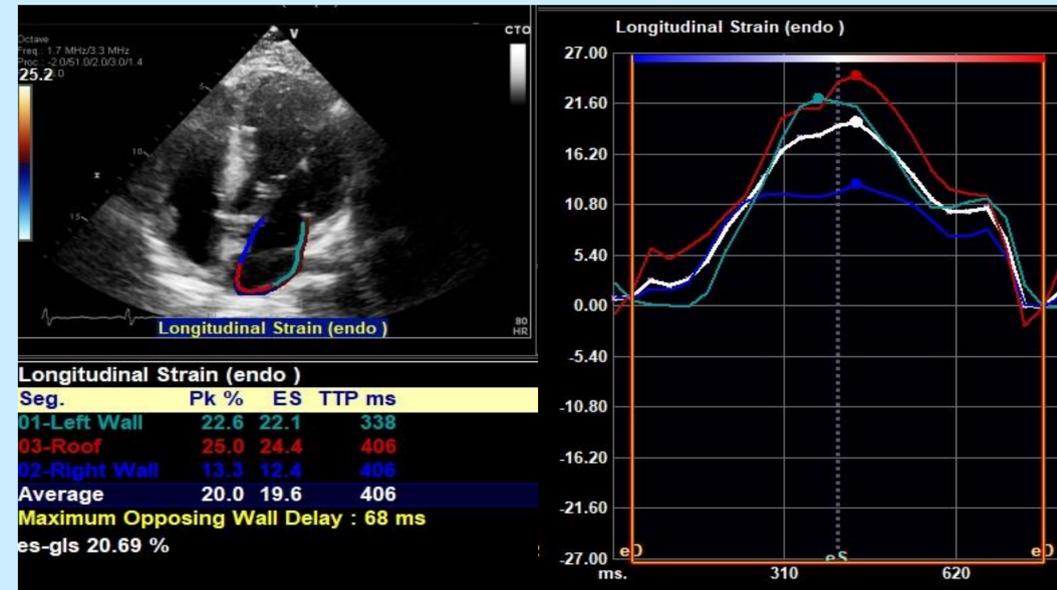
Example of reduced reservoir left atrial (LA) strain in a COVID-19 patient who developed atrial fibrillation, with average LA strain 20% (normal generally considered >38%). A) shows manual tracing of LA endocardial border in apical 4-chamber view with corresponding segmental strain values below. B) is a graphical display of each segmental strain according to color over time of atrial relaxation and white as the chamber average.
